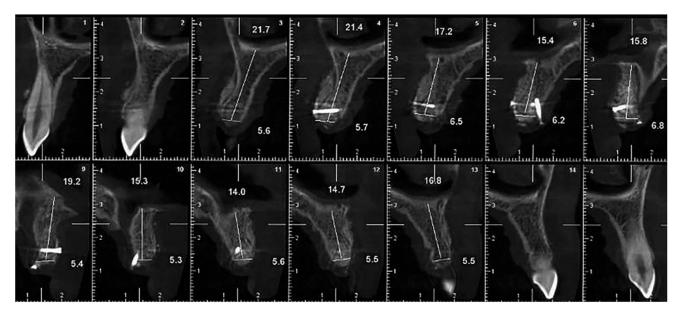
Cone-beam computerized tomographic images 4 months after the surgery showed optimal 3-dimensional ridge reconstruction.
